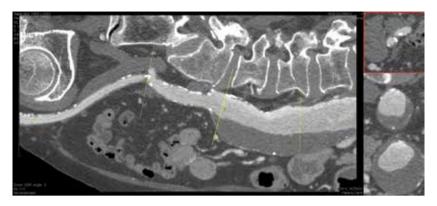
Multi-sliced angio-computed tomography image showing longitudinal and transverse views of large abdominal aneurysm and calcified common iliac artery
